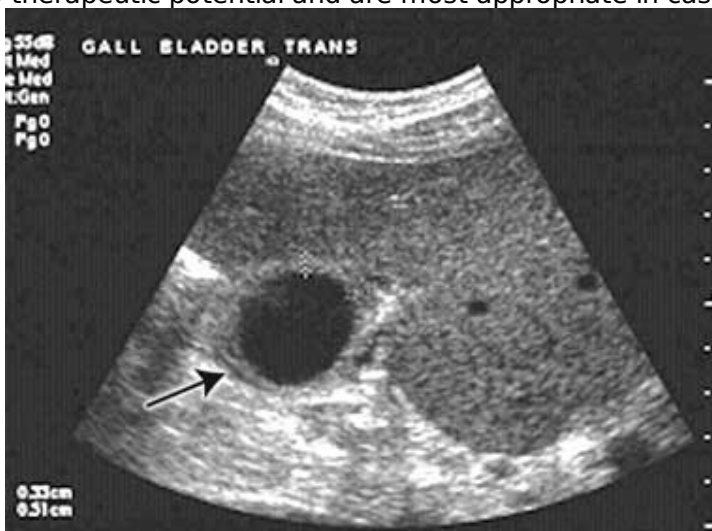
Ultrasound examination showed a thickened gallbladder wall and pericholecystic fluid
